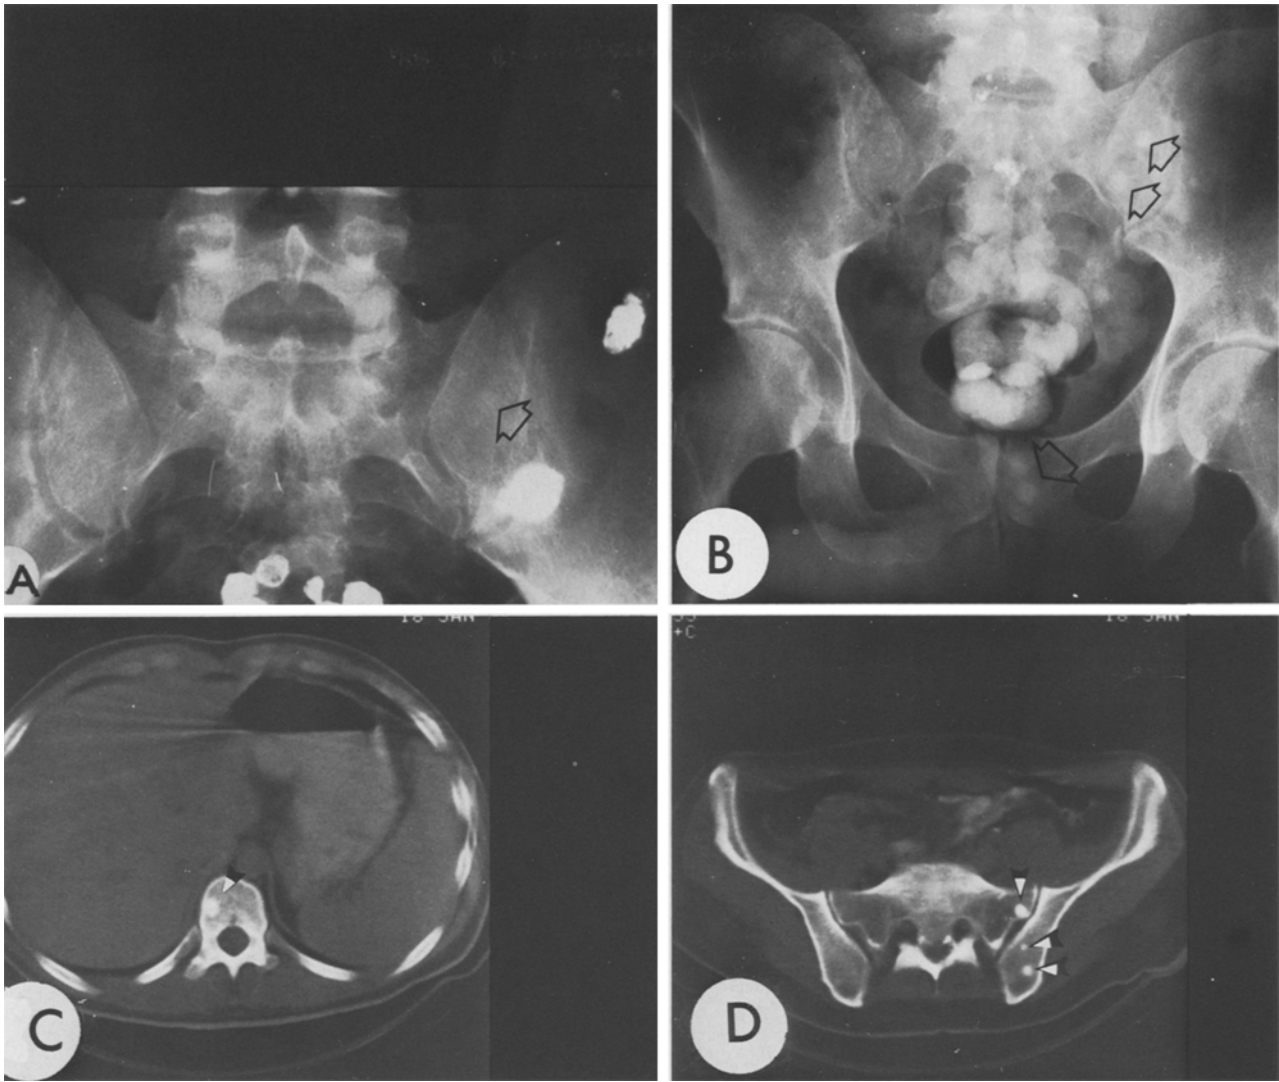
A Plain X-ray film taken 6 weeks prior to admission. An open arrow points to obscure density which later proved to be a metastatic lesion as shown in B. B Plain X-ray film taken 9 days after craniotomy. Open arrows point to circular densities in the pelvic bones identified as metastatic foci. C and D Scan of vertebra and pelvis showing metastases (*arrow heads*)
